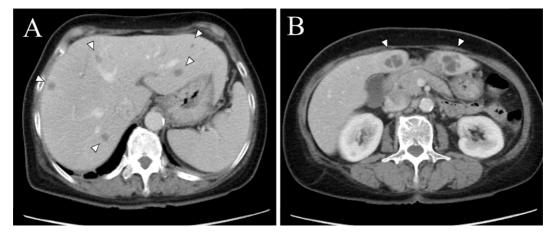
A, B: Multiple intrahepatic low-density areas (arrowheads) on abdominal CT.
